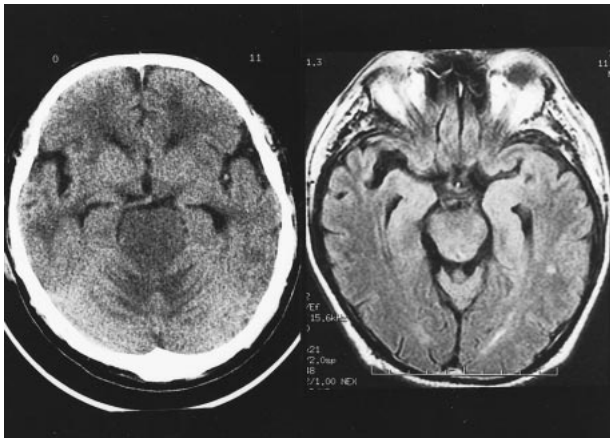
Left*, Axial CT cuts show hypodense, swollen pons. Obliteration of upper fourth ventricle has resulted in enlarged temporal horns.
